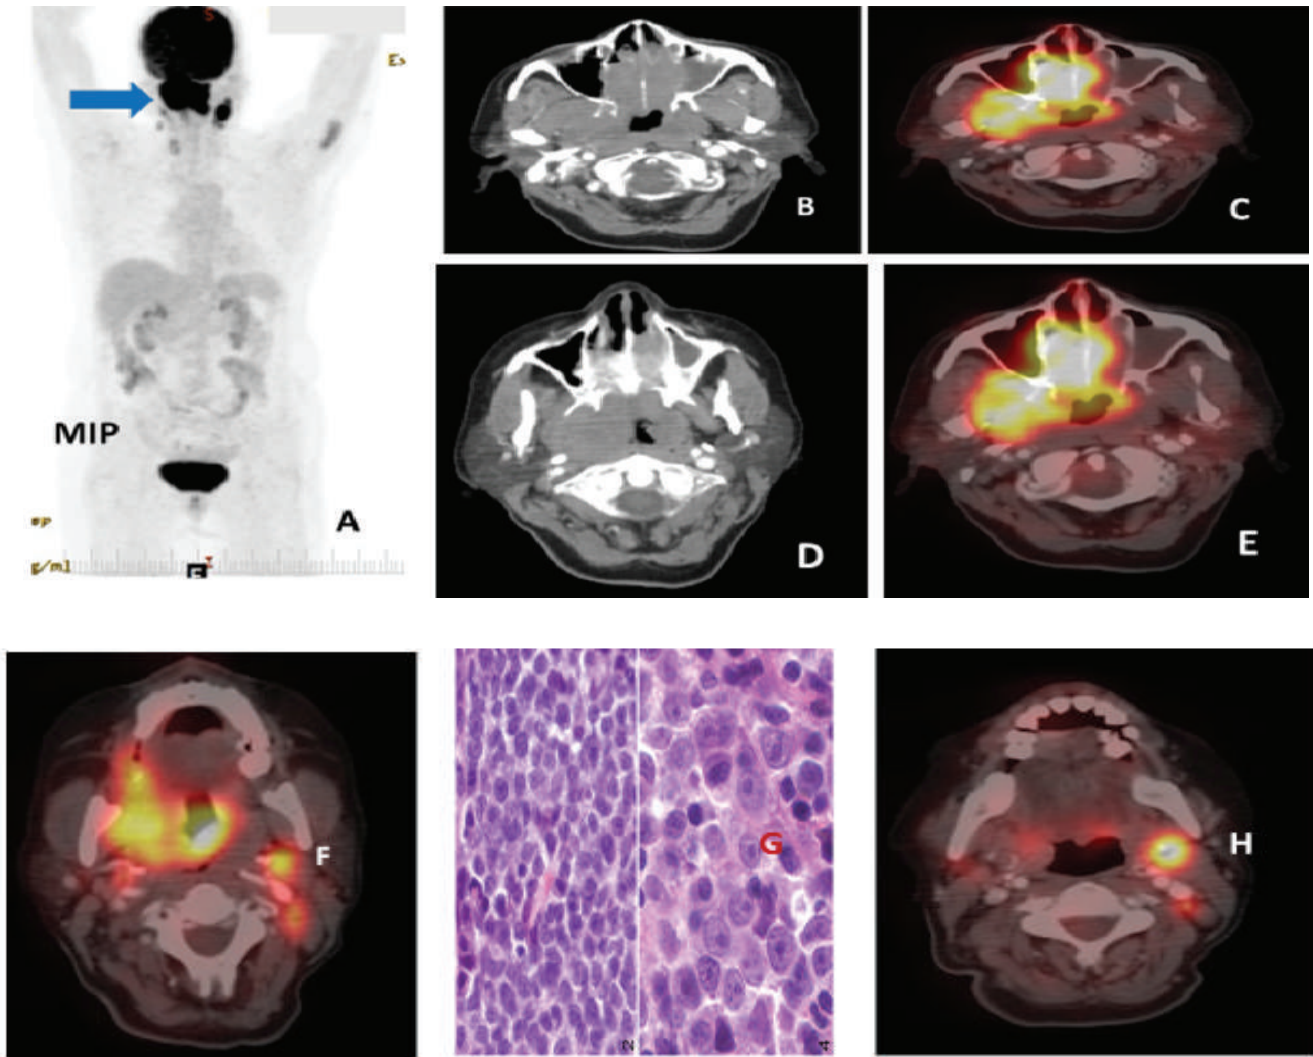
A 55 years old female patient presented with epistaxis and nasal obstruction. Nasopharyngeal laryngoscopy revealed bilateral nasal mass that’s bleeds on touch occupying and obstructing both posterior choana. Nasopharyngeal biopsy from the lesion confirmed DLBCL. FDG PET-CT showed hypermetabolic enhancing irregular soft tissue mass involving the nasopharynx, nasal cavity (A-E). The mass also involving right pterygopalatine fissure, right pterygopalatine fossa, pterygomaxillary fissure (B, C, D) foramen rotundum, adjacent pharyngeal wall and hypopharynx (G). Hypermetabolic few enlarged left cervical lymph nodes. No other hypermetabolic visceral, nodal or skeletal lesion.
